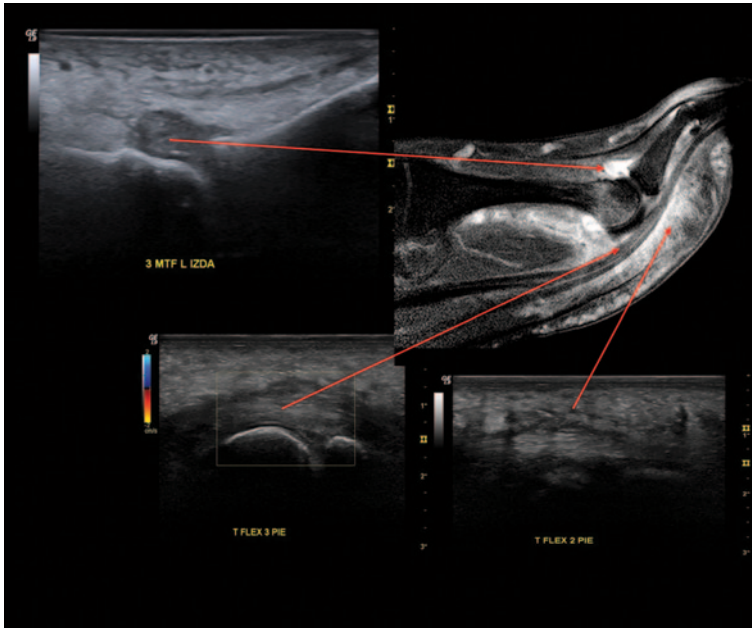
Ultrasound image of the different tissue compartments involved in dactylitis. Comparison with MRI image from the same patient with psoriatic arthritis (*long arrows*). a Synovitis affecting the metatarsophalangeal joint: distension of the joint capsule with hypoechoic content. b Flexor tendon tenosynovitis consisting of a thickening of the diameter of the tendon, with loss of the normal tendon echotexture. c Extratendinous soft tissue changes which are consistent with thickening of the subcutaneous tissue, with an increase of distance from skin to tendon and changes to the echotexture pattern of the soft tissues around the tendon. *MRI* magnetic resonance imaging
